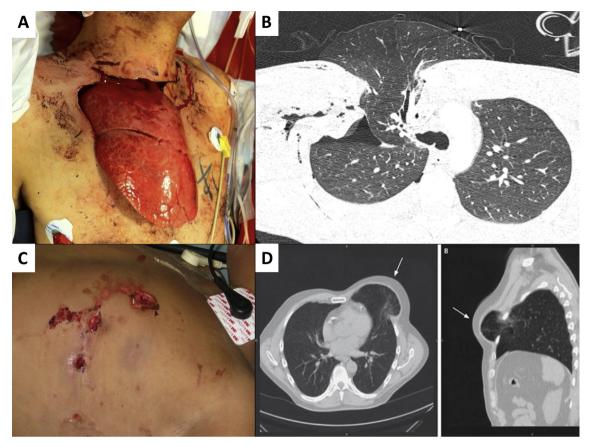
Examples from our cohort of gross (A/C) and corresponding radiographic (B/D) imaging of acute TRCH.
